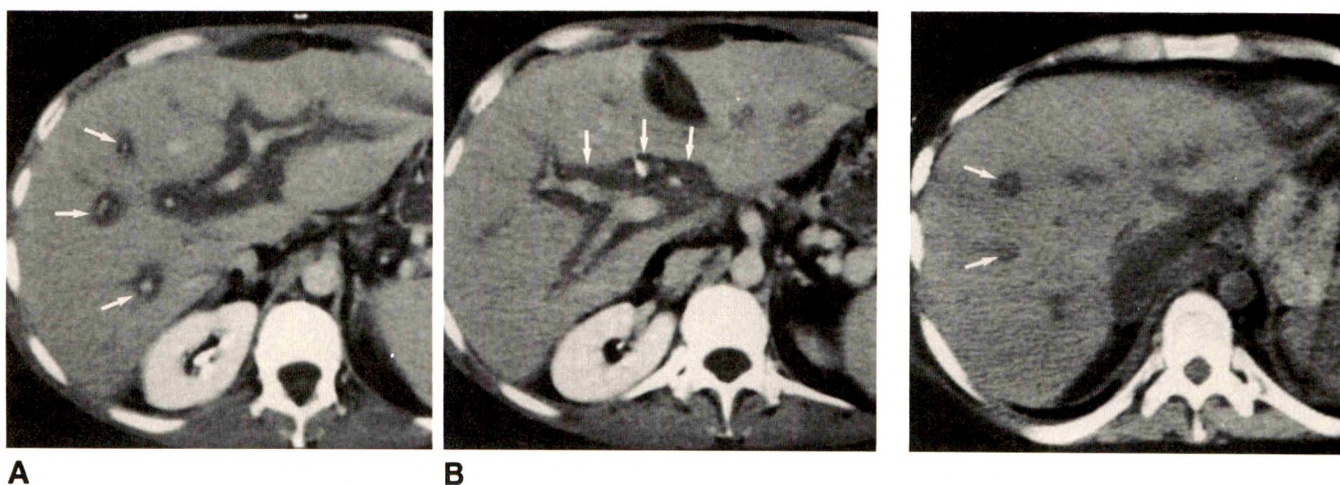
CT scans with IV contrast material show periportal low attenuation in patient with biopsy-proved acute hepatic allograft rejection.
